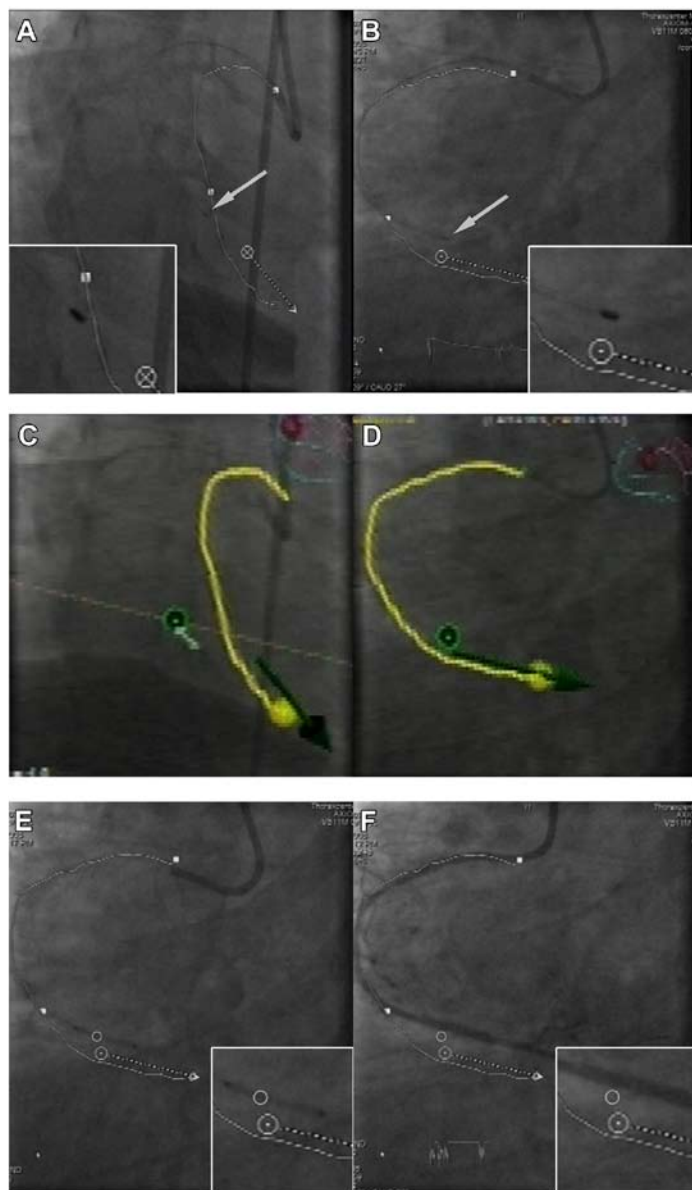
A and B) Radiographic recordings of two orthogonal images IVUS probe positioned in the middle of the lesion and C and D) these two points co-registered as a new reference point (green circle) in the 3D space of Navigant®; E) the overlay of the location of this point (open white circle) on the live fluoroscopic was used to position the stent on the middle of the lesion; F) The stent being deployed following a single “safety check” angiogram.
